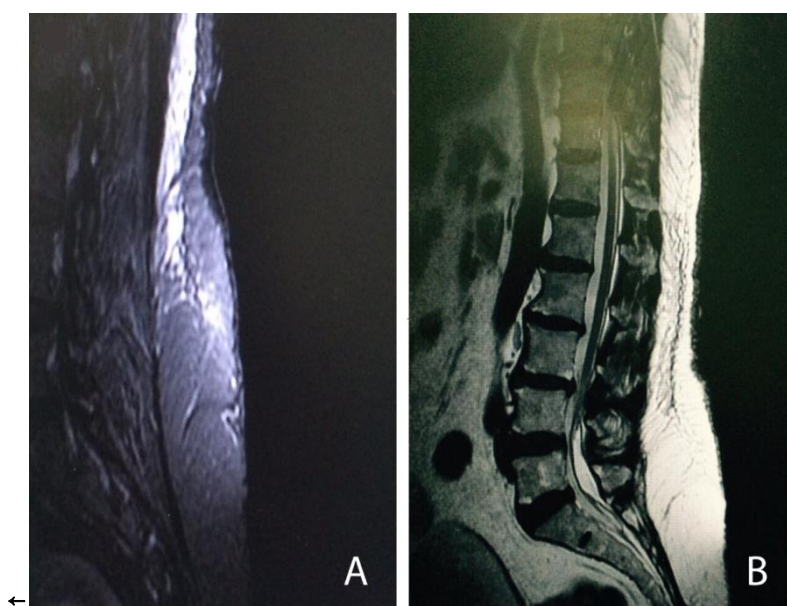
T2 MRI shows L4 tethered cord
